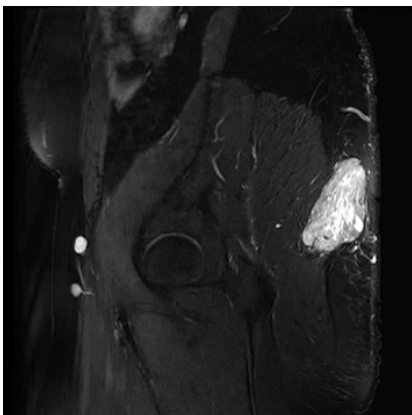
MRI T1WI image.
